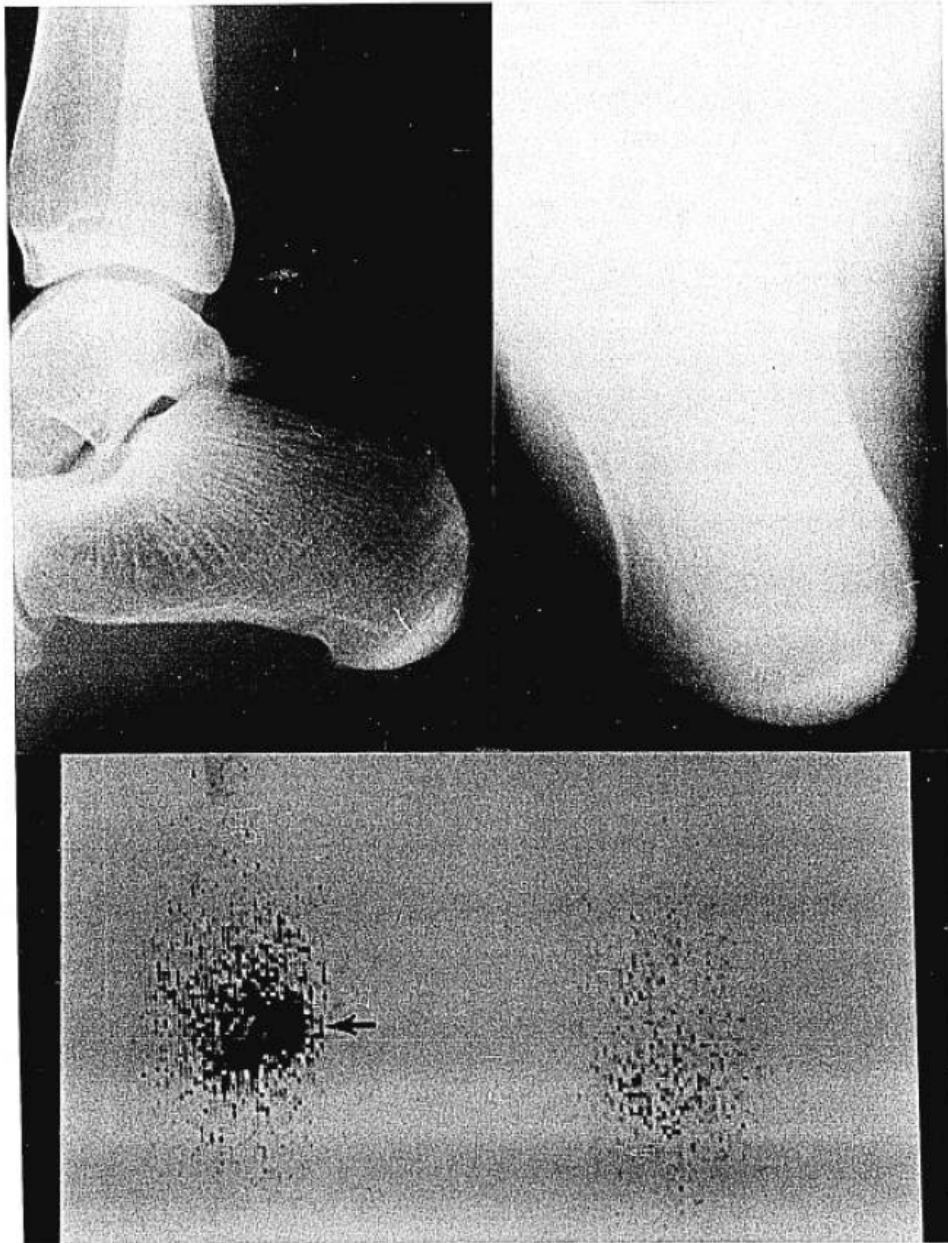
(Patient 25) Lateral (*top left*) and plantar (*top right*) roentgenograms of calcaneus show no fracture. (*Bottom*) Plantar scintiscan of both heels shows focal area of increased activity in right calcaneus (arrow).
